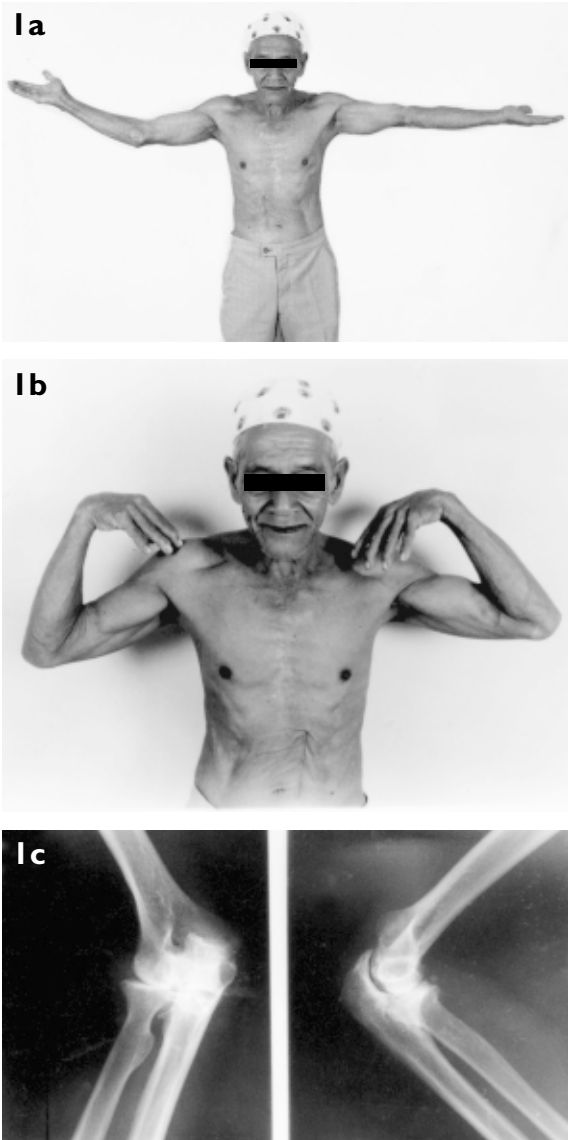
Case 2. (a, b) Clinical photographs of a 60-year-old man show the range of flexion - extension at the right elbow that is preserved after eleven-and-half years following open reduction. (c) AP and lateral radiographs of the right elbow, at eleven-and-half years after open reduction, show gross degenerative changes but the patient still retained a painless range of motion.
